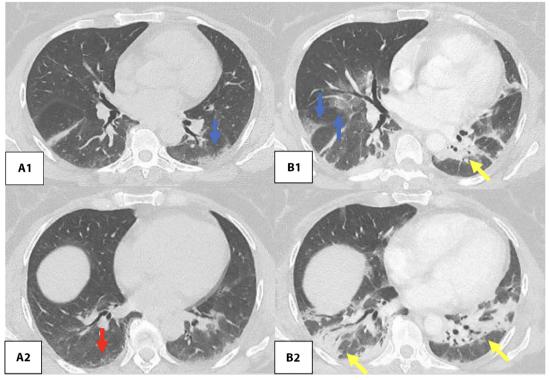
Example of acute exacerbation of ILD Axial images of CT (A1-2 and one month later B1-2) chest demonstrating acute, rapid progression/exacerbation of interstitial lung disease in a 58-year-old woman with underlying rheumatoid arthritis on rituximab. Underlying subtle peripheral reticulation (red arrow) present with developing ground glass opacities (blue arrows) and consolidation (yellow arrows).
